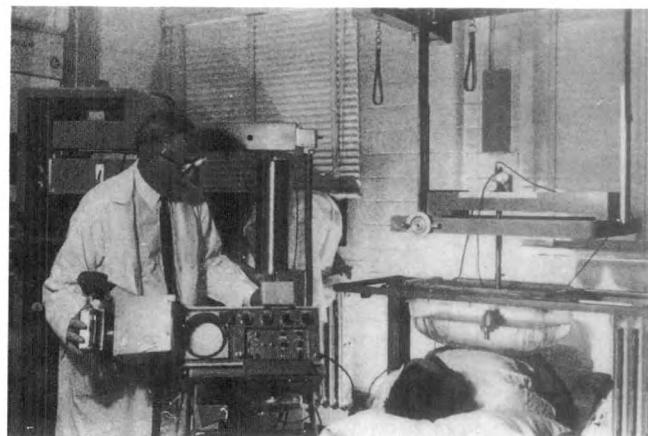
J. Stauffer Lehman scanning a patient with a compound scanner built by Smith Kline Instruments and General Precision Instruments. Transducer moved in a water bath lowered over patient's abdomen. (Reprinted with permission from *Medical Diagnostic Ultrasound: A Retrospective on Its 40th Anniversary*.)
